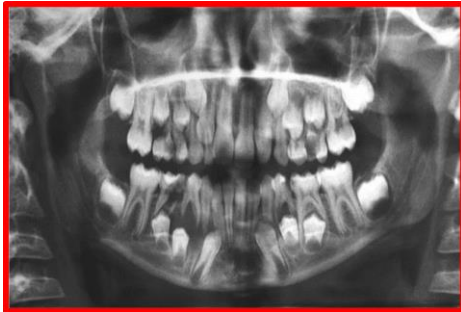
Panoramic radiograph shows dental caries involving the pulp in 85 and well defined periapical radiolucency in the region of 84 and 85 involving the furcation areas of the teeth.
